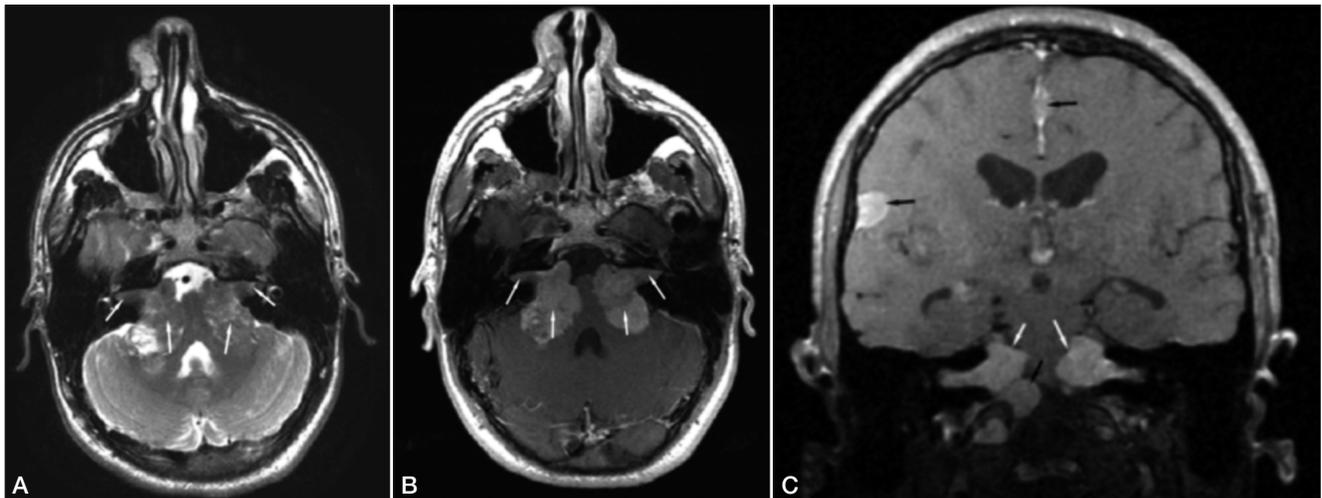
Axial T2-weighted (A) and T1-weighted contrast enhanced (gadolinium) (B) magnetic resonance images of the brain in an adolescent with Nf2 showing bilateral schwannomas (as hypointense lesions: white arrows) with intracanalicular extension (outer white arrows); (C) Coronal T1-weighted contrast enhanced (gadolinium) magnetic resonance image of the brain in a child with NF2 showing bilateral schwannomas (as hyperintense lesions: white arrows) and multiple meningiomas (black arrows).
